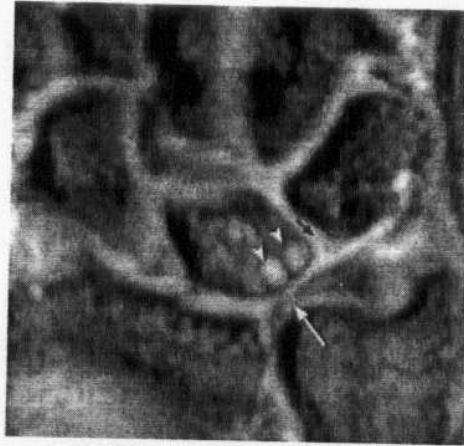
Ulnar impaction syndrome in a 41-year-old man with positive variance and chronic ulnar-sided wrist pain. Coronal gradient-echo MR image reveals central TFC perforation (white arrow), subchondral cystic changes in the lunate bone (arrowheads), and a lunotriquetral ligament tear (black arrow) (Quoted from Cerezal et al., 2002).
